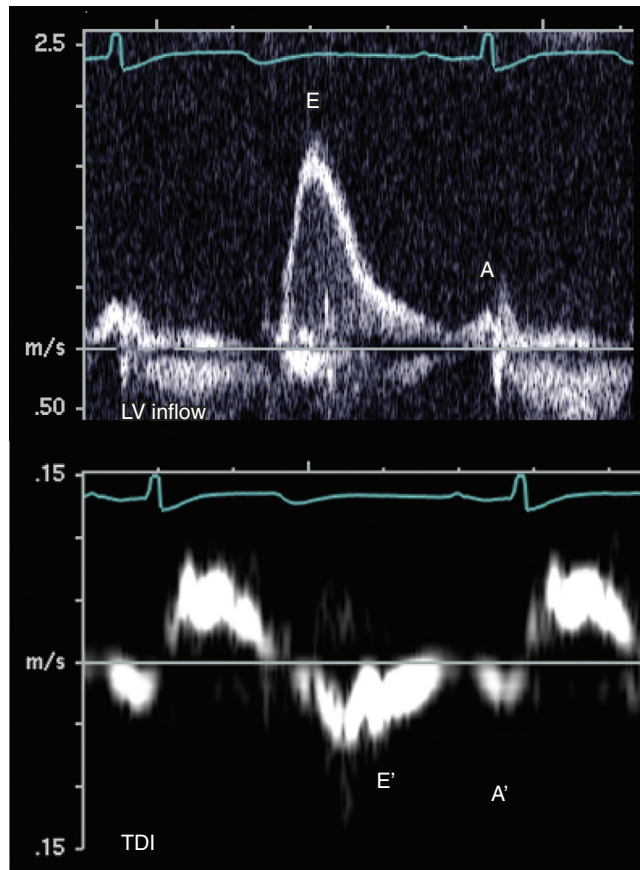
■ With advanced diastolic dysfunction (restrictive filling), there is decreased left ventricle (LV) compliance. High left atrial pressures drive transmitral filling with a higher, early peaked E wave and E:A ratio greater than 2. A ratio of LV inflow E wave to tissue Doppler velocity (TDI) E' wave (E:E' ratio) greater than 15 implies elevated left atrial pressure. In this case, $E:E' = 1.7/0.07 = 24$.
